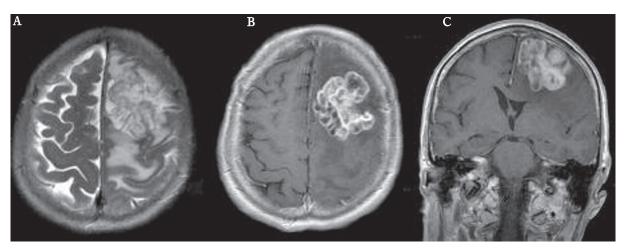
A) Axial T2-weighted magnetic resonance (MR) image showing hyperintense mass in the left frontal lobe with surrounding oedema; B) axial and C) coronal T1-weighted MR images revealing ring enhancement of the lesion
